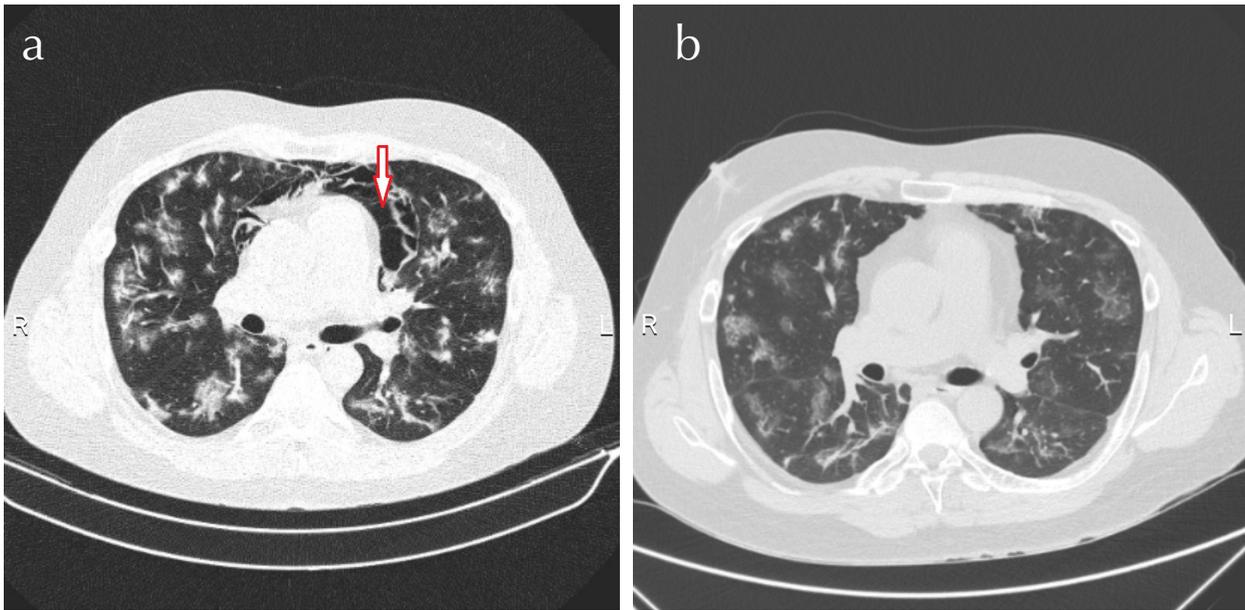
(a) Pneumomediastinum in the chest CT scan, (b) The patient's pneumomediastinum improved
